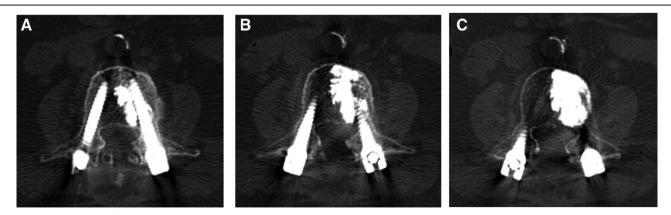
Postoperative axial CT scan showed the bone cement filling the body and around the screw.
